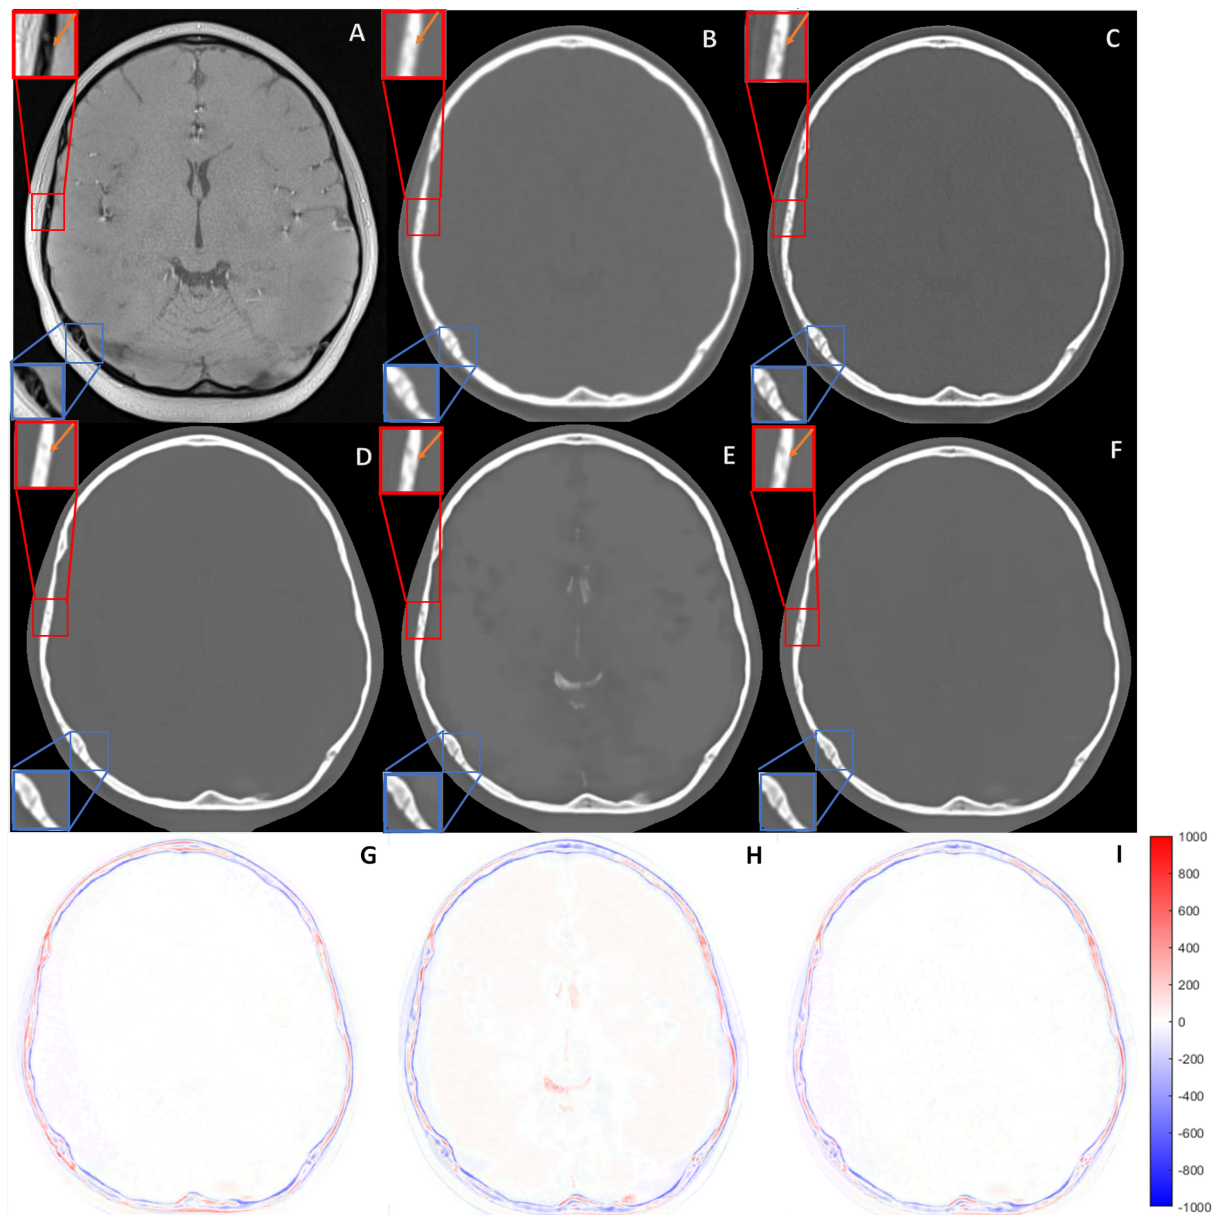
Representative Images from a patient (4.8-year-old, male). The blue squares mark the lambdoid suture, while the red squares mark the coronal suture. MR images (A), CT (B), BM3D filtered CT (C),  $pCT_{NetWH}$  (D),  $pCT_{NetBA}$  (E),  $pCT_{Com}$  (F), and the corresponding difference images ( $pCT_{NetWH}-CT$ ) (G), ( $pCT_{NetBA}-CT$ ) (H), and ( $pCT_{Com}-CT$ ) (I)
